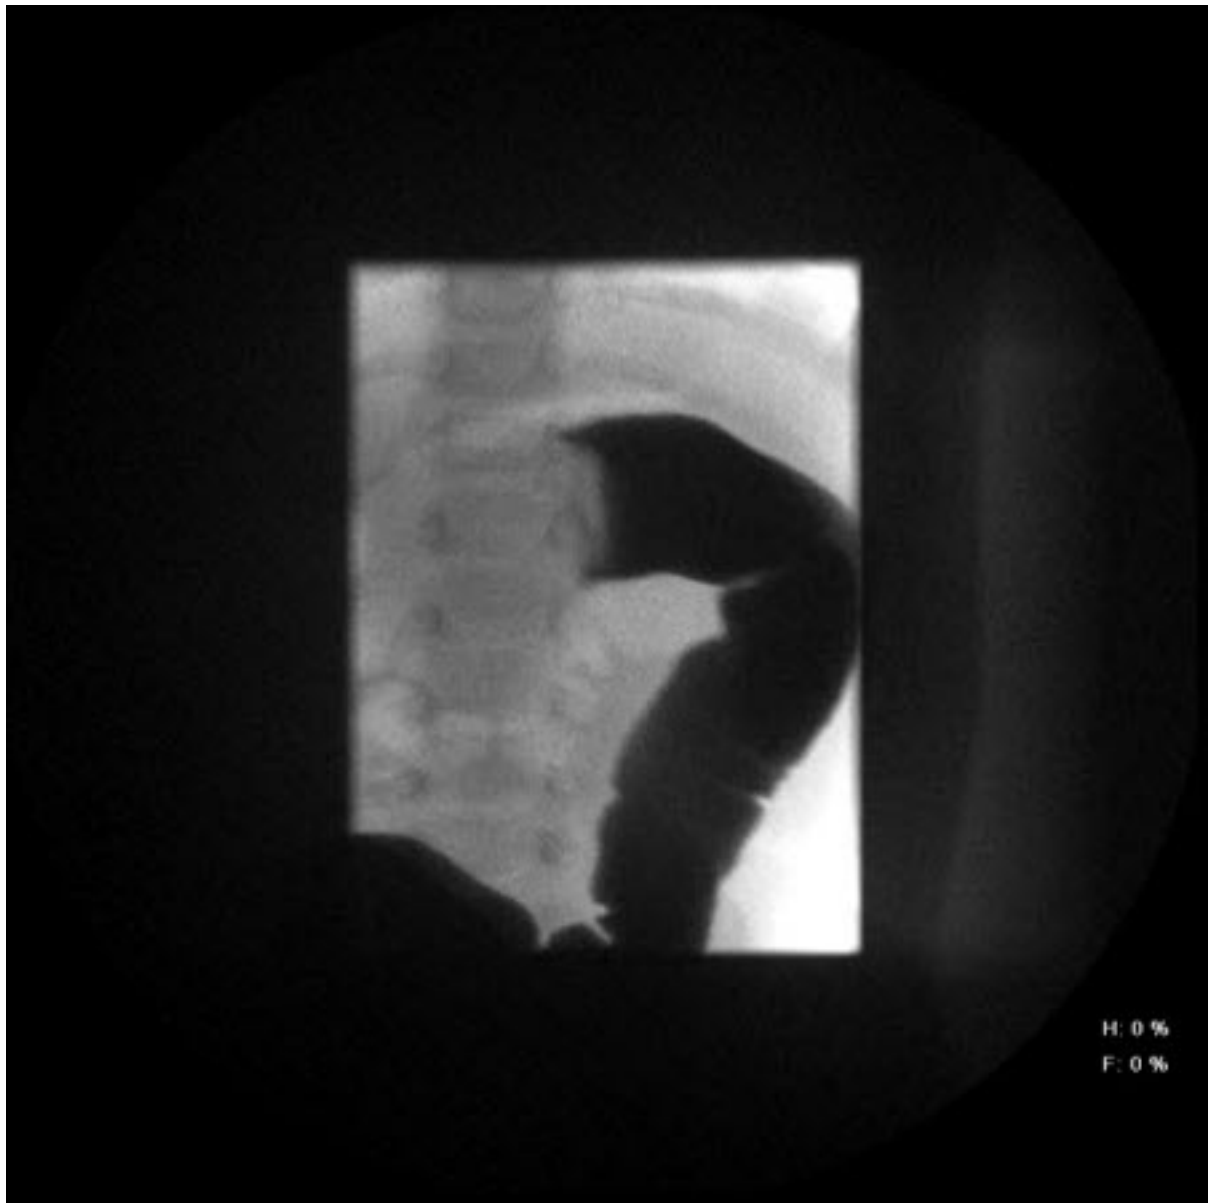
Intussusception: Abdominal x-ray showing impaired passage of barium at site of obstruction due to intussusception
